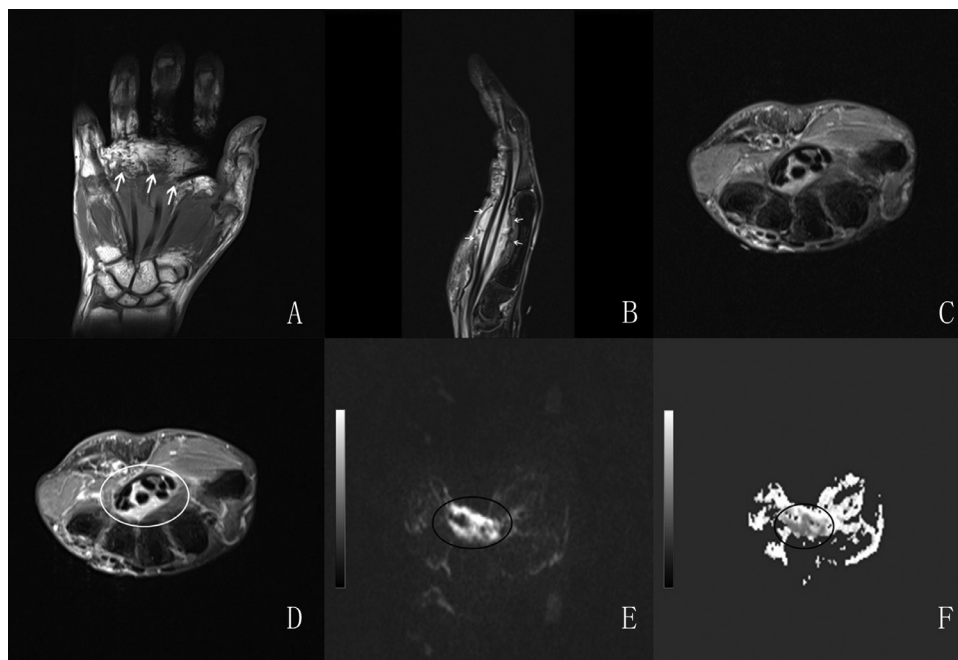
Magnetic resonance images of the right wrist and hand: (A) Coronal T1-weighted image demonstrates a slightly decreased signal intensity tissue lesion surrounding the flexor tendon(arrowheads). (B) Sagittal, T2-weighted, demonstrating the increased signal within the lesion(arrowheads). (C) Pre-contrast and (D) post-contrast axial proton density images at the level of the right wrist joints demonstrate a overall and homogeneous enhancement of the lesion in the carpal tunnel(circle). (E) Coronal DWI shows that some lesions were diffused and limited. (F) ADC shows slightly decreased or decreased signal of lesion.
